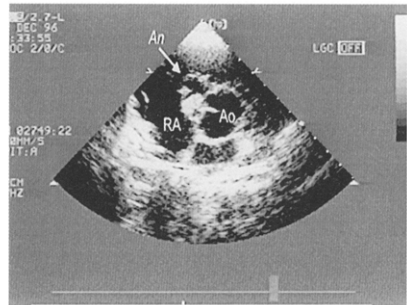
Parasternal short-axis view of 2 clots inside inter-ventricular aneurysm (*An*). *LA*, Left atrium; *RA*, right atrium; *LV*, left ventricle; *RV*, right ventricle.
